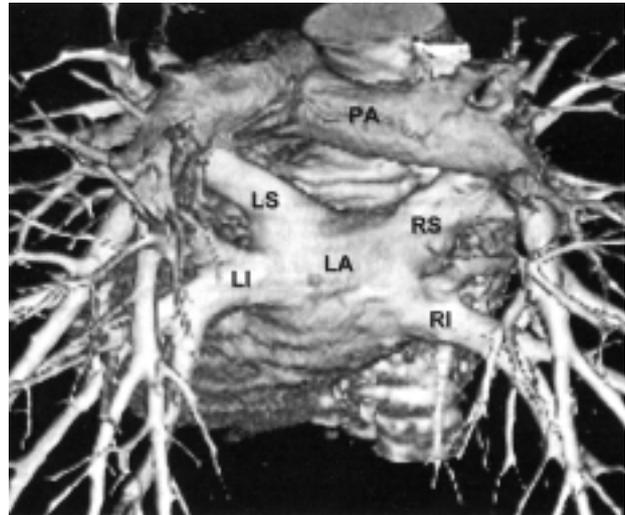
Three-dimensional reconstruction of the heart with spiral computed tomography. In the postero-anterior view, the posterior wall of the left atrium (LA) and the four pulmonary vein ostia are observable. The right superior pulmonary vein (RS) os is slightly dilated. LI = left inferior pulmonary vein; LS = left superior pulmonary vein; PA = pulmonary artery; RI = right inferior pulmonary vein.
